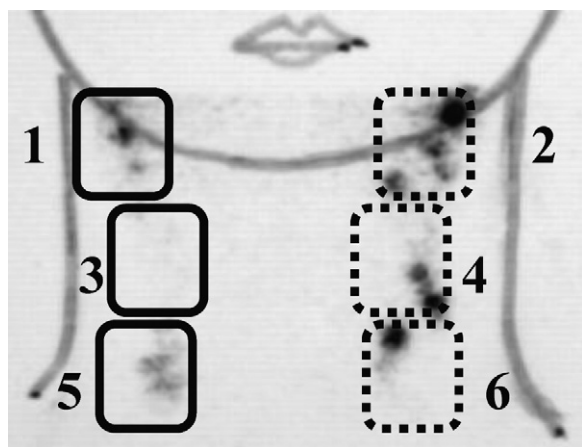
Regions of interest (ROI) of cervical lymph nodes of dynamic lymphoscintigraphy. They were the right and left superior levels of internal jugular nodes (ROI numbers 1 and 2), the mid internal jugular nodes (3 and 4) and the inferior internal jugular nodes (5 and 6).
